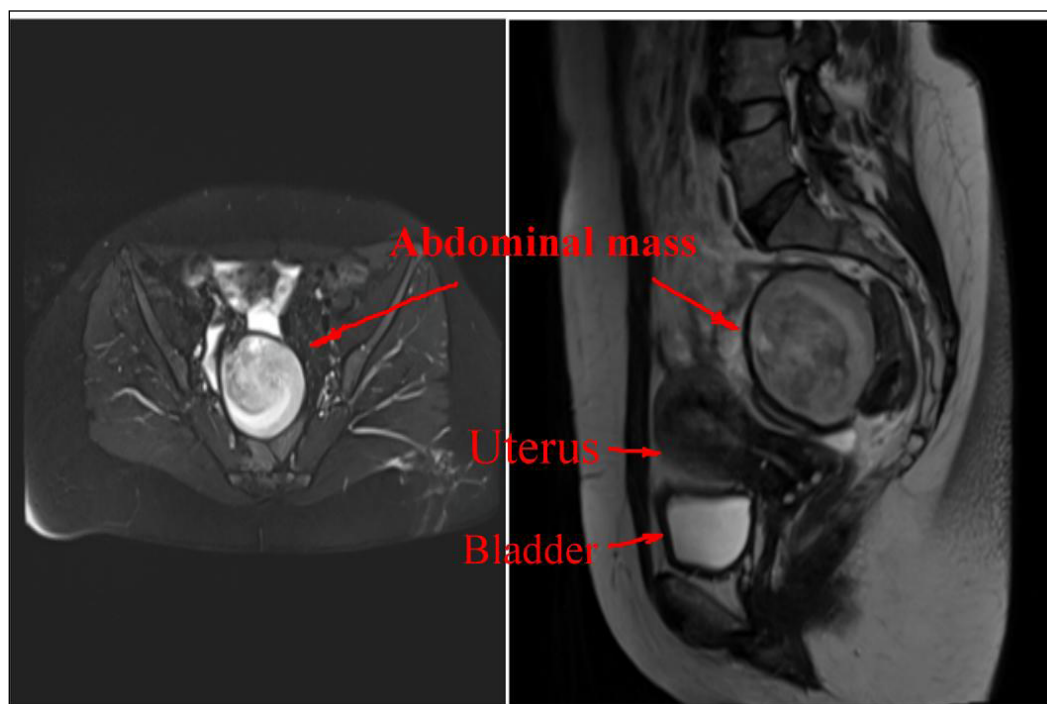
MRI of the abdominal cavity. Abdominal mass.
